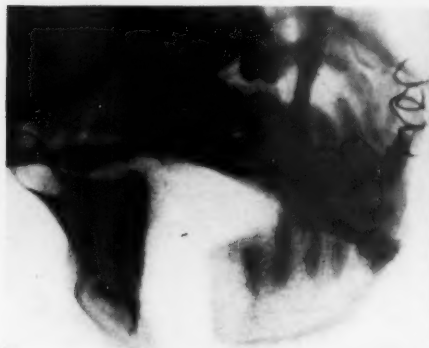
(Case 2.) Roentgenogram made after resection of involved portion of mandible (Dr. Carl Kornblum).
